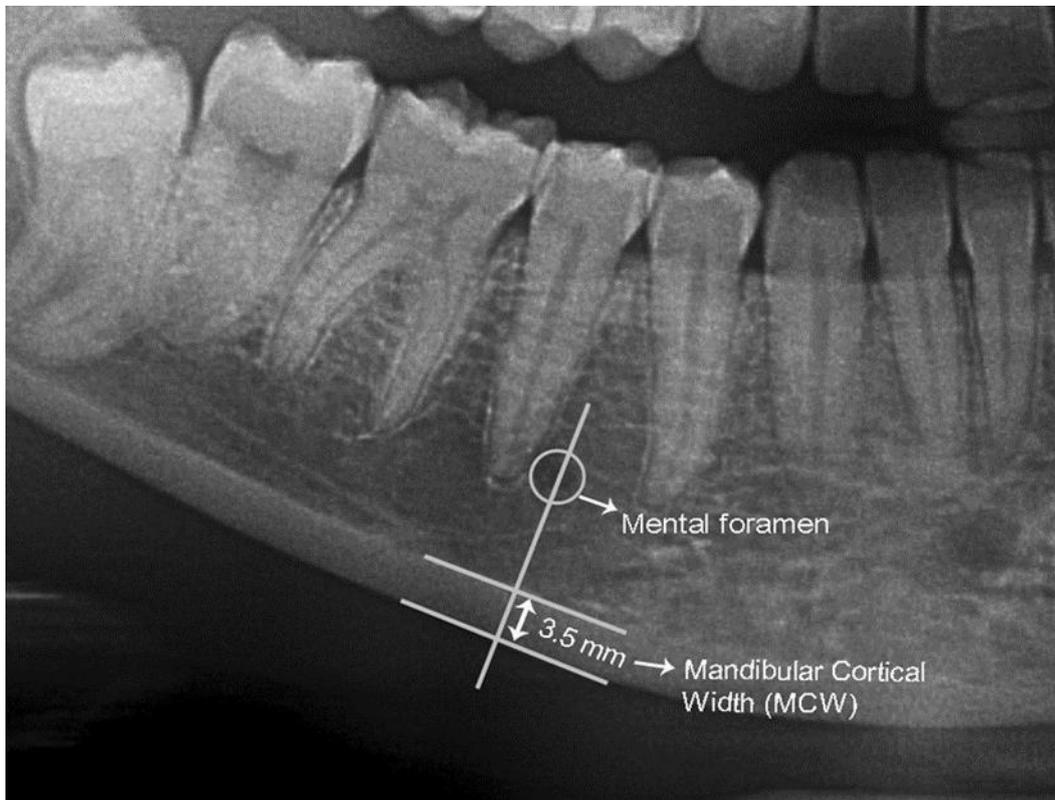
MCW index is visible in a cropped panoramic radiograph. (Camila NAO Kato,2020).
